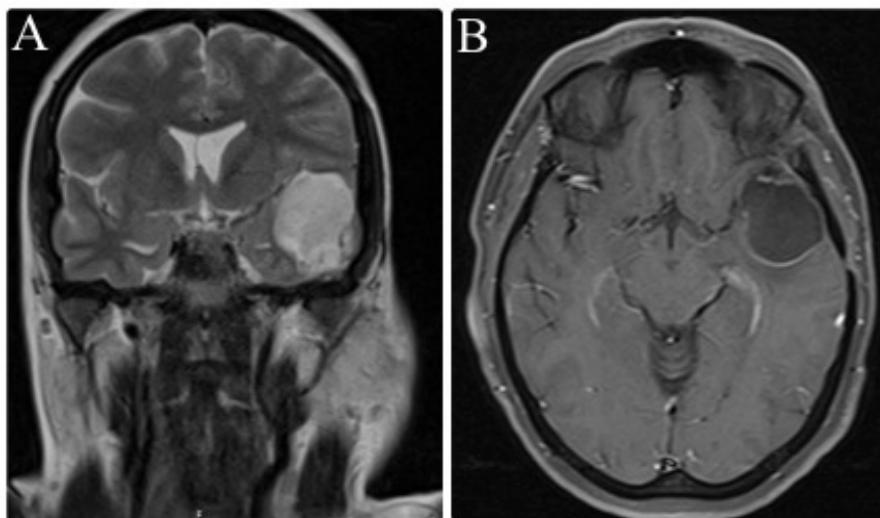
A. Coronal T2-weighted MRI revealed a cystic lesion measuring approximately 31×30 mm in the left anterior temporal region, which appeared hyperintense. B. Axial T1-weighted MRI following intravenous contrast administration demonstrated a lobulated cystic lesion with peripheral contrast enhancement and mild surrounding vasogenic oedema.
